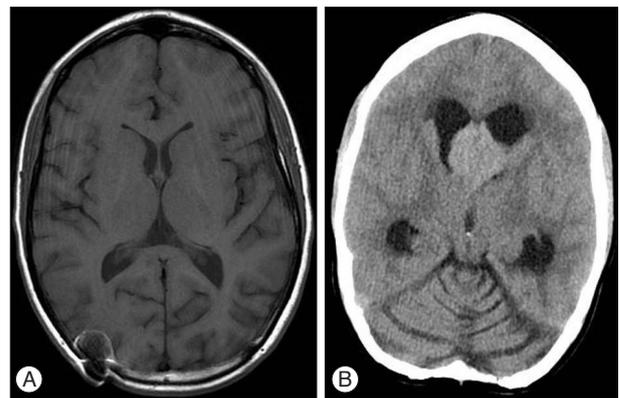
CT brain without contrast (B) showing a septal lesion causing obstruction of the foramen Monro resulting in obstructive hydrocephalus. (A) MRI of the brain without contrast on 7/14/2009 last scan prior to recent presentation.
